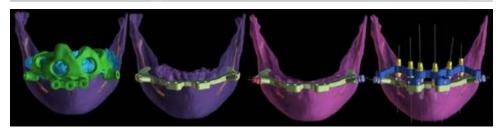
Intraoral and CT scans were obtained using the dual scan protocol. Additionally, the CT was submitted to Diagnocat for bone segmentation to generate STL models of the jaws. All of these data were brought into Blue Sky Plan to position the implants.
